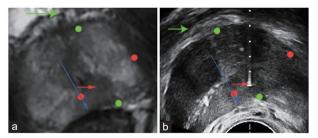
Representative (a) T2-weighted magnetic resonance image and (b) ultrasound image of the prostate in a patient. The red arrow indicates the suspected lesion in the prostate; the green arrow shows the public bone; and the blue arrow identifies the mid-line of the prostate in the axial plane. The x-axis (red dots) and y-axis (green dots) extend across the center of the suspected lesion. In this patient, the lesion was located in the prostate's posterior third of the y-axis and along the inside third of the x-axis. In the ultrasound image, we first identified the red arrow and the green arrow, then we identified the x- and y-axes based on the relative location of the blue arrow. The lesion was then located in the MRI image in the prostate's posterior third of the y-axis. MRI: magnetic resonance imaging.
